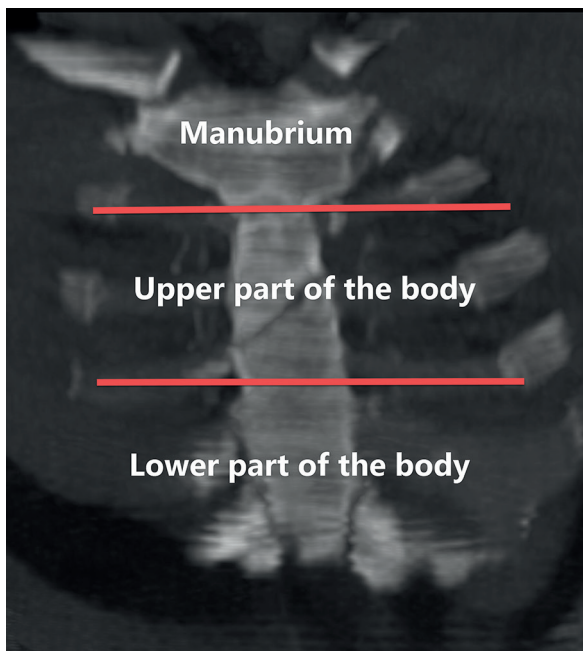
Coronal reformatted chest CT image shows the sternum parts; manubrium, the upper or lower half of the sternal body.
